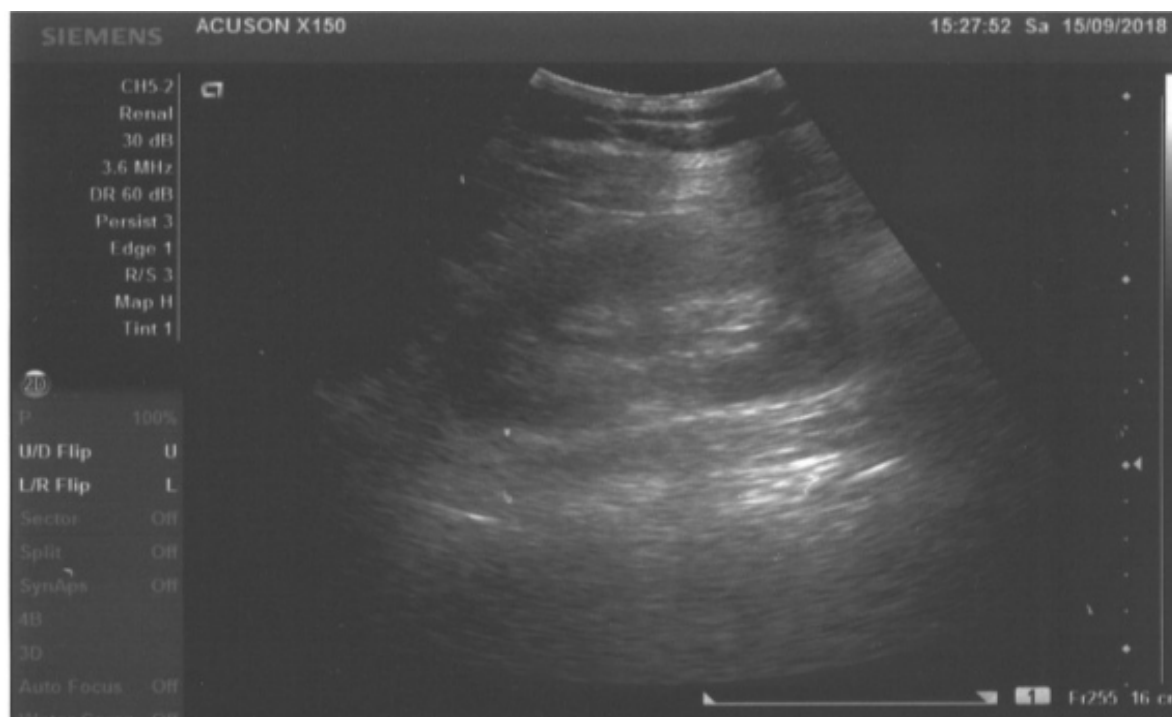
Control ultrasonography of the right kidney, with no sign of hydronephrosis.
